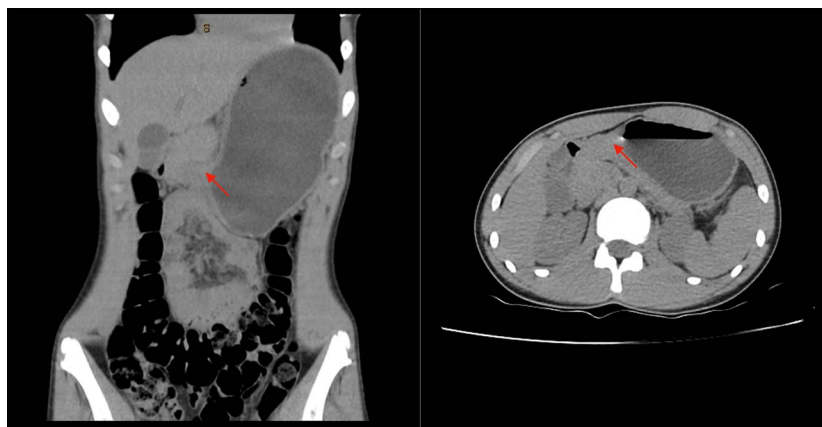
Axial CT showing fluid-filled stomach with the thickened wall and tapering at the antrum and pylorus (red arrow) with the corresponding coronal view. CT, computed tomography.
